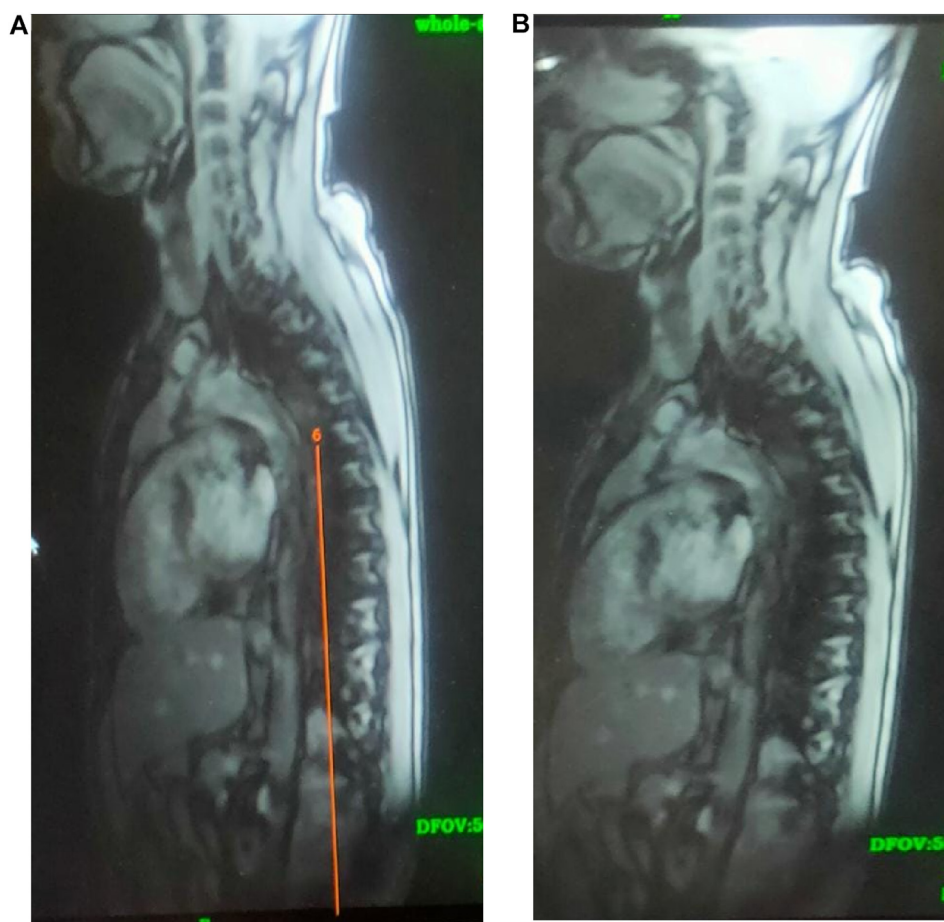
(A and B) MRI lumbosacral spine revealed involvement and collection at psoas muscle with edema at T11-L2.
